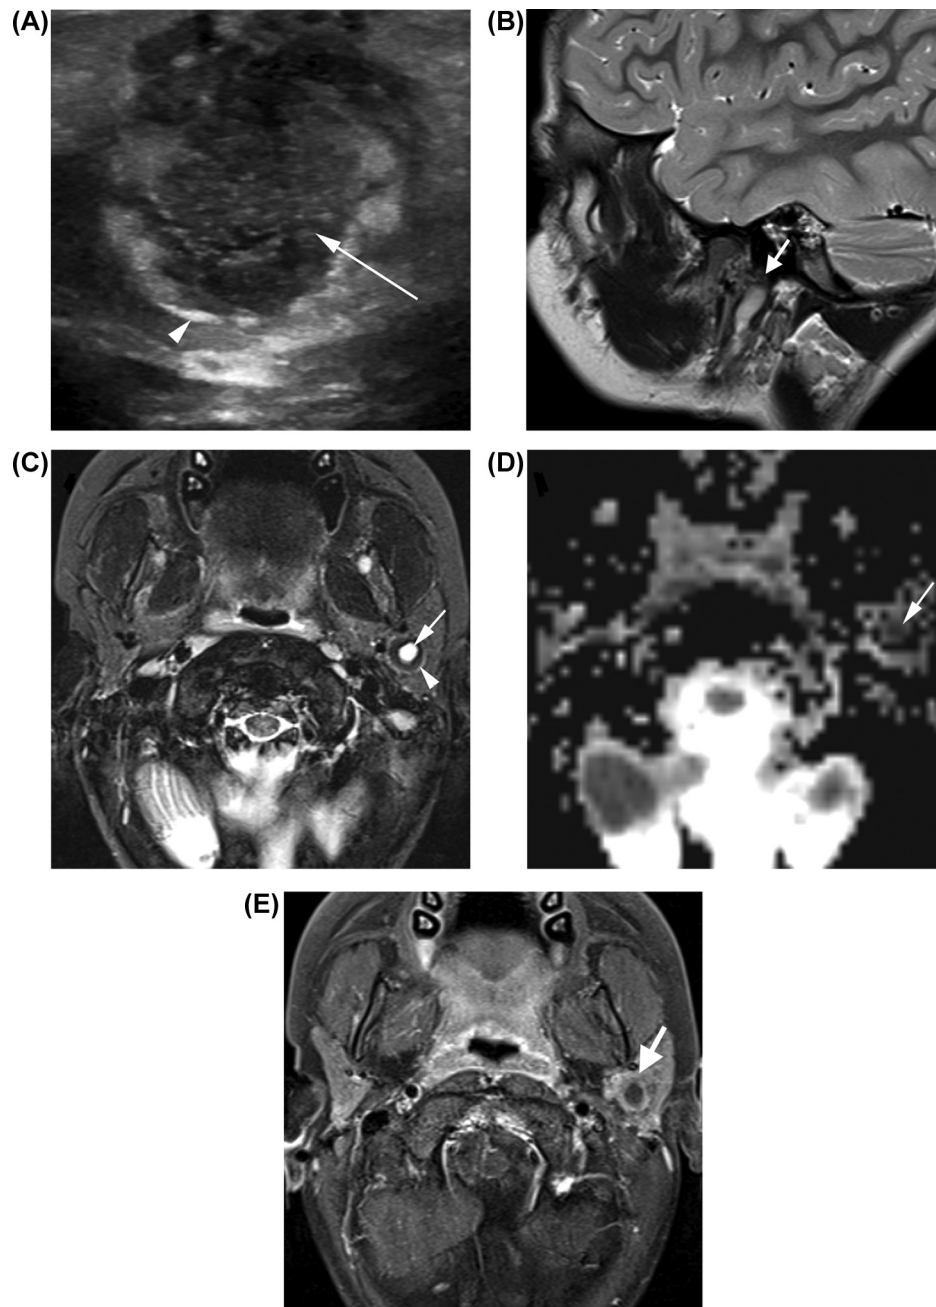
(A) Ultrasound image demonstrates an irregularly shaped heterogeneous lesion (arrow) that contains multiple moderately echogenic mural foci (arrowhead), surrounding edema and inflammatory change. (B) Sagittal T2 weighted MR image shows a tubular lesion (arrow) along the posterior aspect of the left parotid gland. (C) Axial T2 short tau inversion recovery image demonstrates the hyperintense lesion (arrow) with hypointense mural thickening (arrowhead) within the left parotid gland. (D) The diffusion weighted image apparent diffusion coefficient map reveals decreased diffusivity within the lesion (arrow) attributable to the keratinaceous content. (E) Axial fat-suppressed T1 weighted image shows peripheral mural enhancement (arrow).
